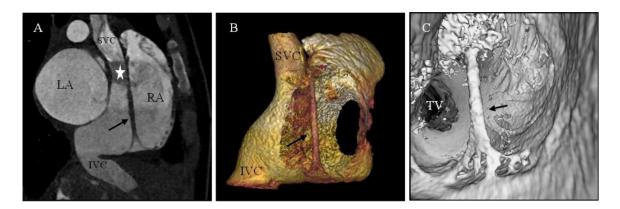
The multiple planar reformation(A), volume rendering(B) and CT virtual endoscopy(C) showed the membrane partition (Black arrow) in RA and slow blood flow (White star) in superior vena cava (SVC). inferior vena cava; TV, tricuspid valve.
